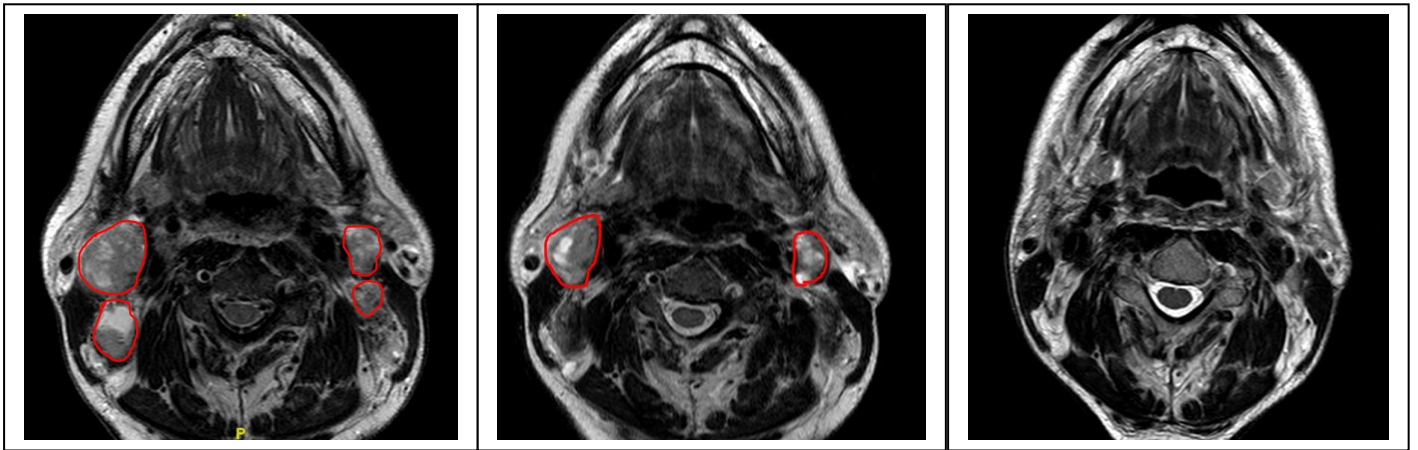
CT scan of a Complete responder showing multiple level II nodes
